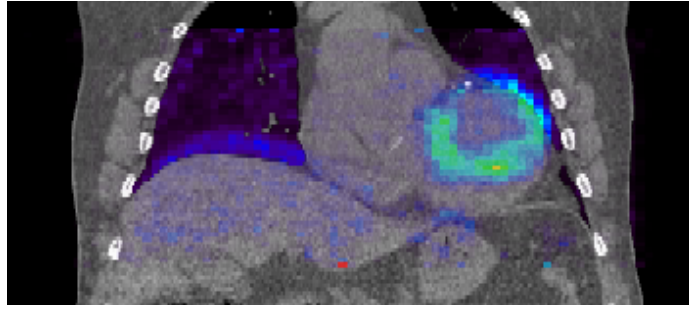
A coronal slice through the end-inhale frame of the CT dataset for patient 2, fused with the end-exhale PET frame for the same patient, demonstrating the maximum level of mismatch through use of the end-inhale CT for attenuation-correction. In this case the PET has been corrected for attenuation with the matched CT frame.
